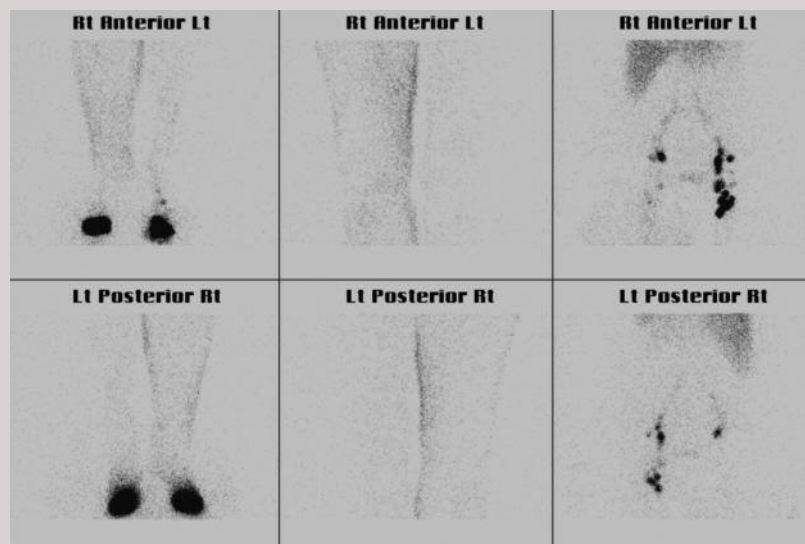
A lymphoscintigram of a patient with congenital lymphoedema (delayed two-hour images – images on left, lower leg; centre, knee and lower thigh; right, upper thigh and groin). The images show dermal backflow in the affected leg and fewer lymph nodes in the right groin. (Note that this patient is not the patient in the case scenario.)
